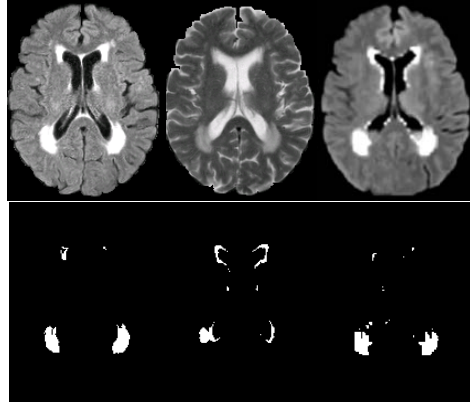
Synthetic FLAIR from a set of T1w and T2w images.
